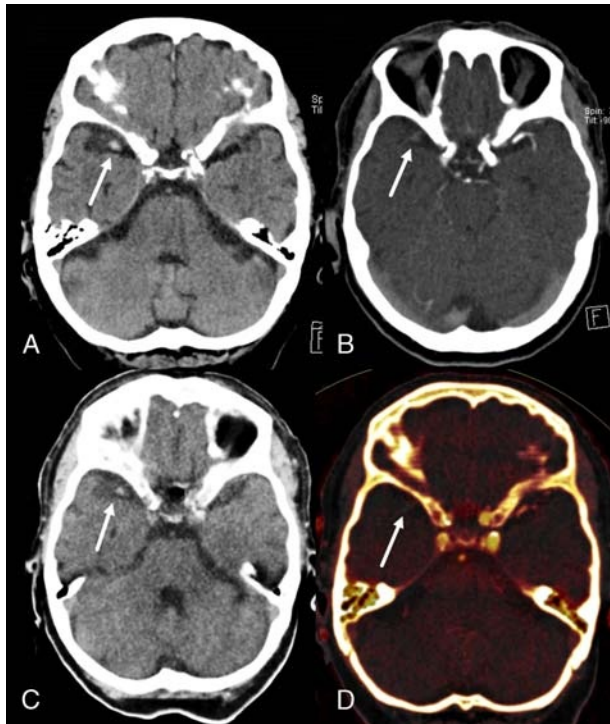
True noncontrast (A), CTA (B), VNC (C), and iodine (D) images of a 66-year-old female patient with acute ischemic stroke. The HAS is clearly visible in both the TNC and in the VNC images (C) (arrow). Note the vessel occlusion with the missing iodine contrast (arrow) in the CTA (B) and in the iodine (D) images compared with the contrast in the vessel on the contralateral side.
